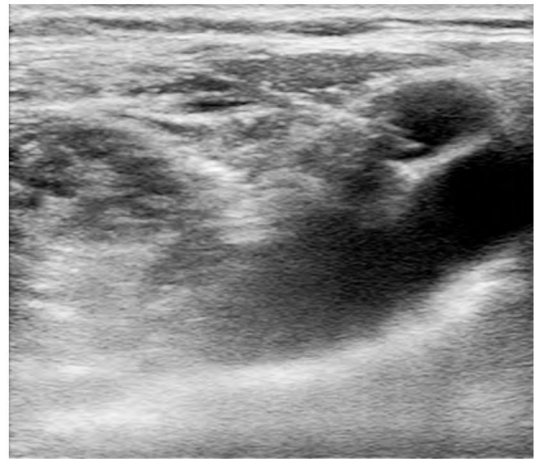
Ultrasound guidance of the needle introduction to venous access, transverse view.
